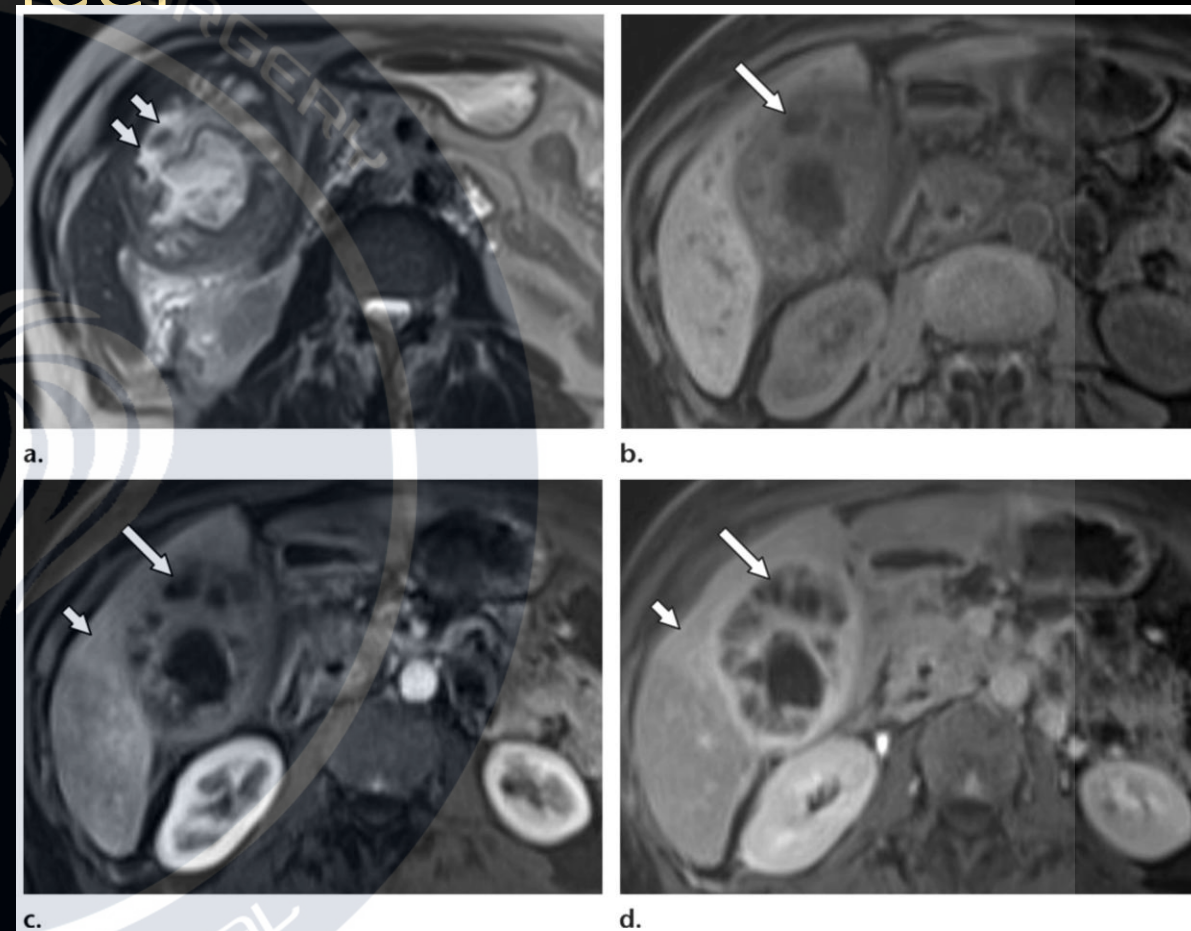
Xanthogranulomatous cholecystitis in a 68-year-old woman. (a) Axial T2-weighted image shows a heterogeneously thickened gallbladder wall with multiple intramural lesions (arrows), which are iso- or hyperintense. (b) Axial T1-weighted image shows hypointense cystic foci (arrow). (c, d) Axial early (c) and delayed (d) contrast-enhanced T1-weighted images show mild arterial and marked delayed enhancement surrounding the cystic foci (long arrow). There is mild surrounding hepatic parenchymal enhancement (short arrow), which is likely reactive.
